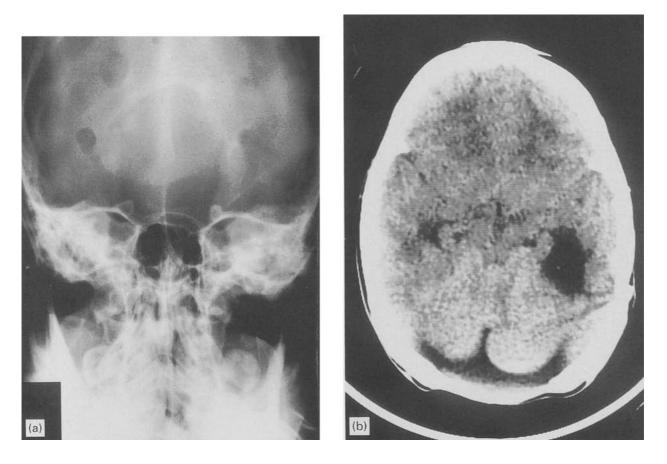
(a) X-ray, antero-posterior. Same patient as Fig. 9; 8 months postoperative. Note: "radiolucency" at the screw sites. Osteoplasty fully integrated, normal shape of foramen occipitale magnum. (b) CT-scan, 8 months postoperative. Same patient as Fig. 9. Note: stable consolidation of transplanted bone, undisturbed growth of the skull.
